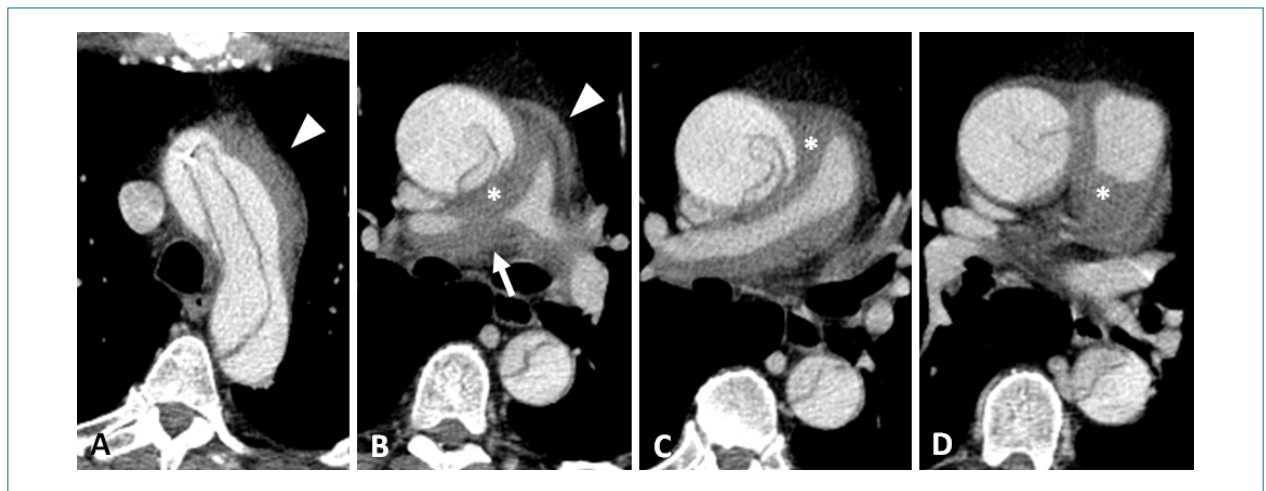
16-row multi-detector computed tomography angiography of the chest (A to D – axial multiplanar reconstruction), shows acute aortic dissection (Stanford type A) associated with secondary hematoma (asterisk), involving the pulmonary artery trunk and its main branches. It is more evident on the right, determining luminal reduction of its proximal portion (white arrow). Note, as well, the mediastinal hematoma in the para-aortic and subaortic regions (white arrowhead).
